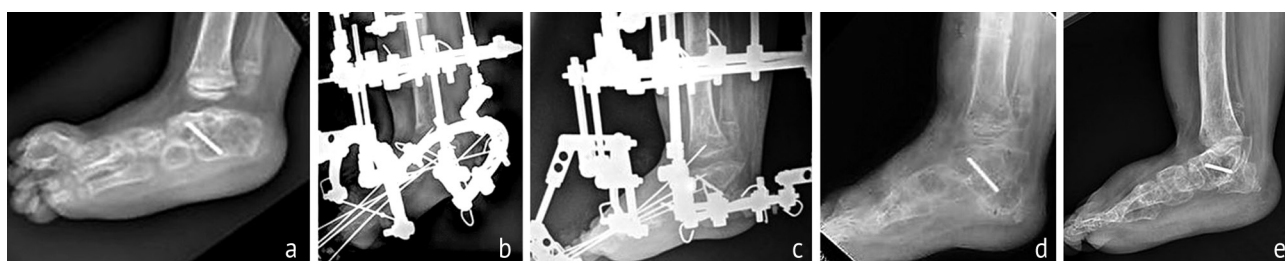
Correction of recurrent deformity of the calcaneus, radiographs (FH type 3C): *a* the foot before the lengthening stage, tibial-calcaneal angle 72° ; *b* at the beginning of foot deformity correction; *c* after correction of the deformity achieved, the angular divergence of the calcaneal fragments is clearly visible; *d* after removal of the Ilizarov apparatus; *e* follow-up after 1.5 years, the treatment result is maintained
